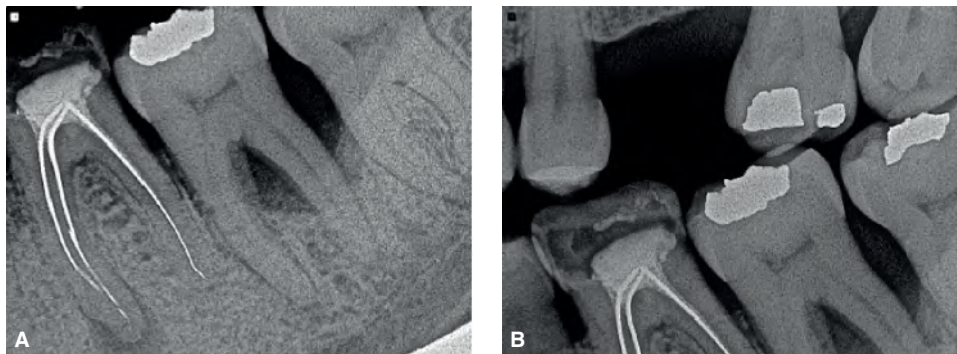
The pulp of the mandibular left second molar is nonvital, possibly due to root fracture. A. Periapical radiograph B. Bitewing radiograph. Severe destruction of intraproximal bone is indicative of primary periodontal involvement. Periodontal probing reached the apical third of the distal root. The prognosis is questionable. Extraction is indicated and should be done as soon as possible to prevent further damage to the bone associated with the adjacent teeth. Implant site preservation is another consideration in treatment planning for this case.
